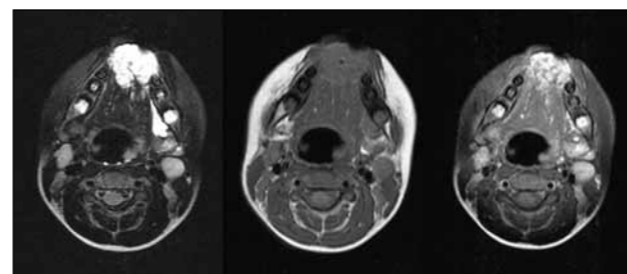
Axial MRI images of a tongue VM acquired using STIR, T1 and T1 post-contrast sequences. These demonstrate a lesion of the anterior one third of the tongue.
